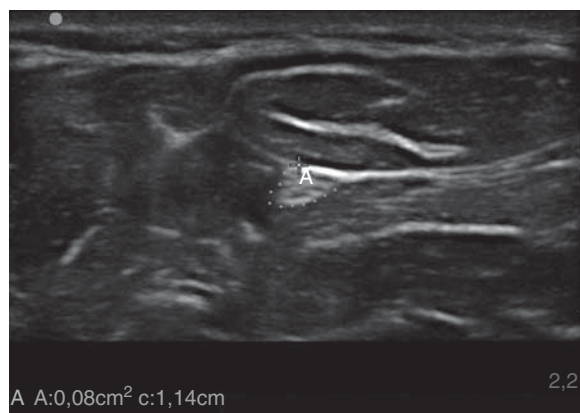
Measurement of the cross-sectional area of the ulnar nerve with ultrasound.
